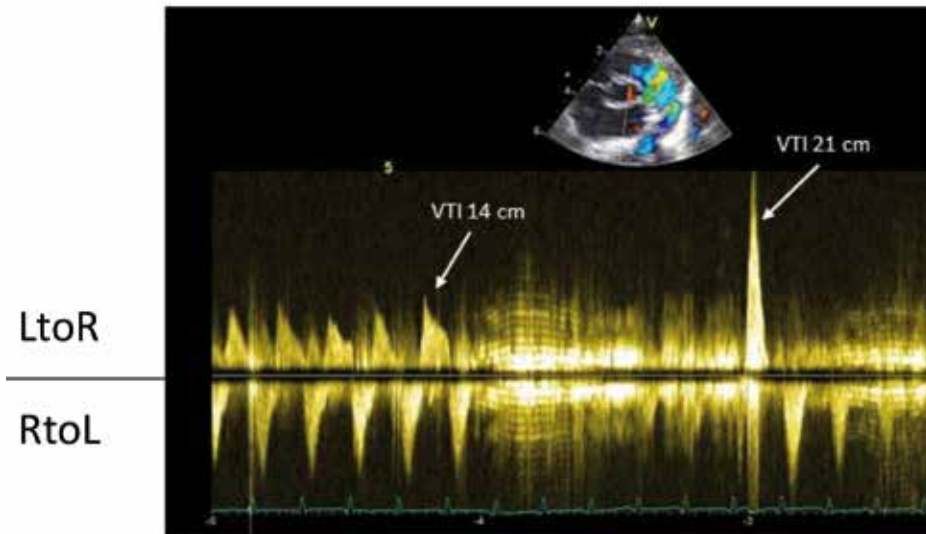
Doppler registration of DA LtoR and RtoL shunting. Noise is caused by crying after which an inspiration of the infant causes a large increase of VTI.
